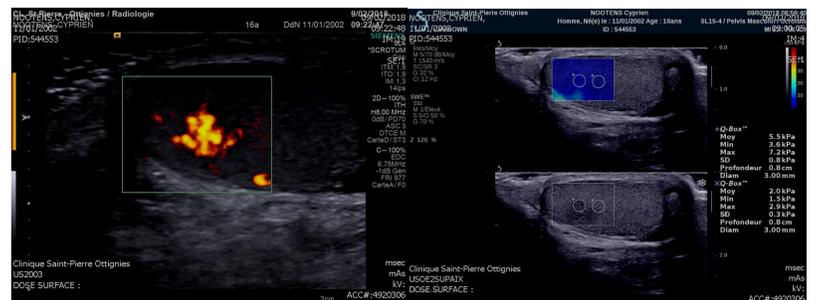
aspect of the nodule at Doppler's signal;
